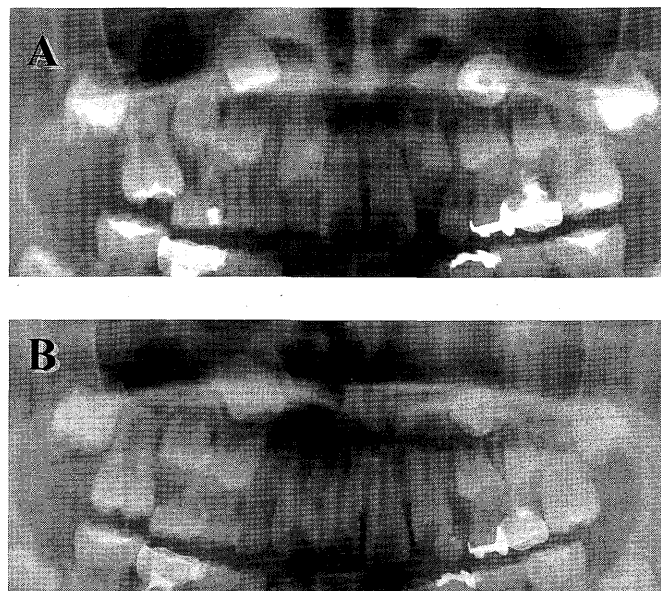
Orthopantomograms at the first visit, aged 7 years and 8 months, (A) and at the revaluation, aged 8 years 5 months (B)
